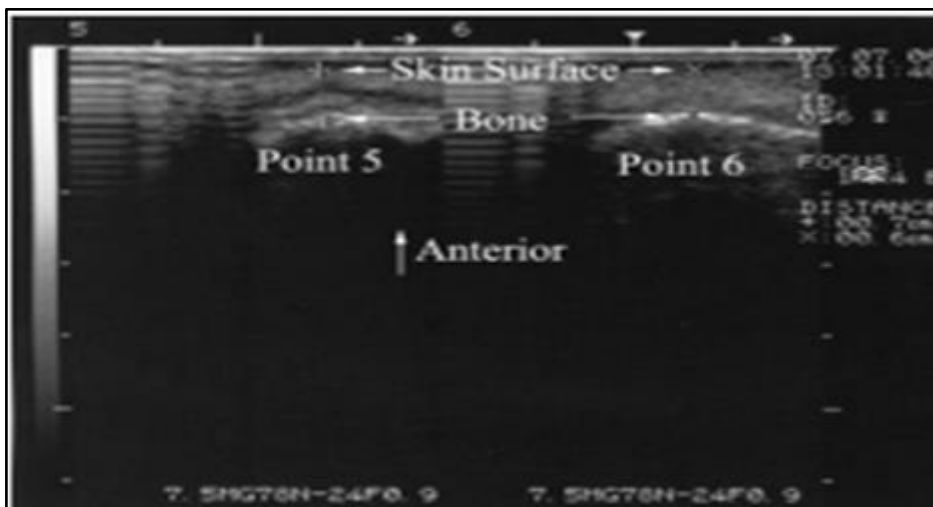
Thermal printout of ultrasound data displaying measurements of 3 landmarks [27]
